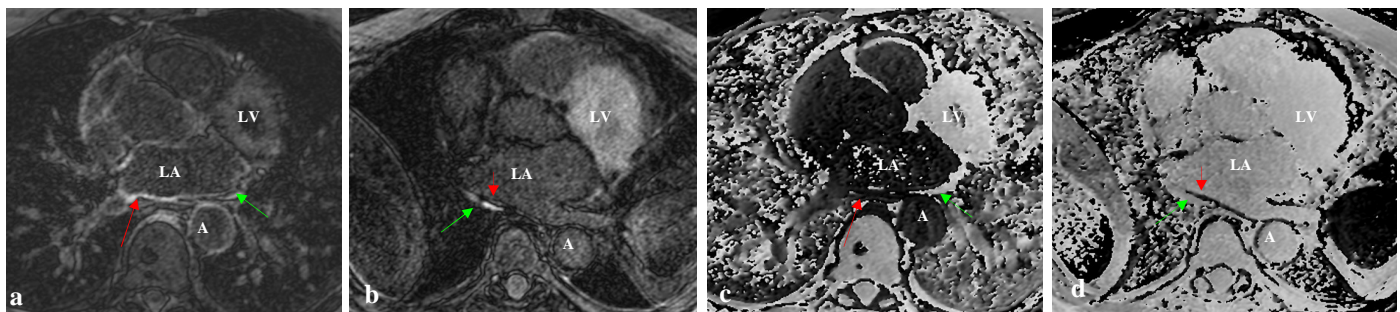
Scar imaging of left atrium using DE-MRI with (a, c) close to optimal TI, (b, d) too short TI. a and b – magnitude images, c and d – phase images. Red arrows indicate post-ablation scar in the posterior wall of LA, green arrows show lipid-rich structure. LA – left atrium, LV- left ventricle, A – Aorta.
